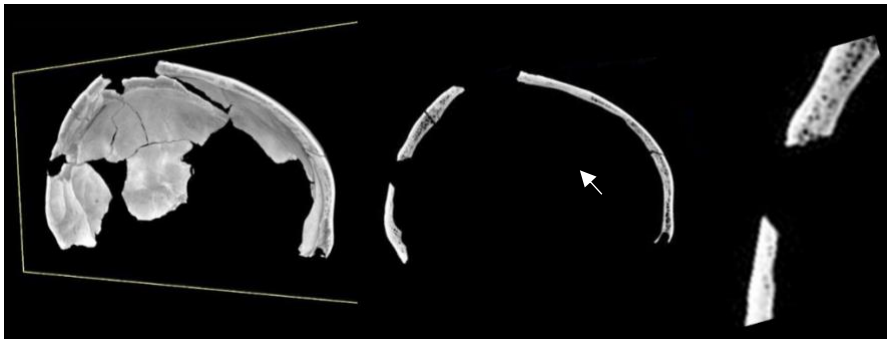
CT images of Case 4, showing cone crack, radiating cracks, and concentric cracks
